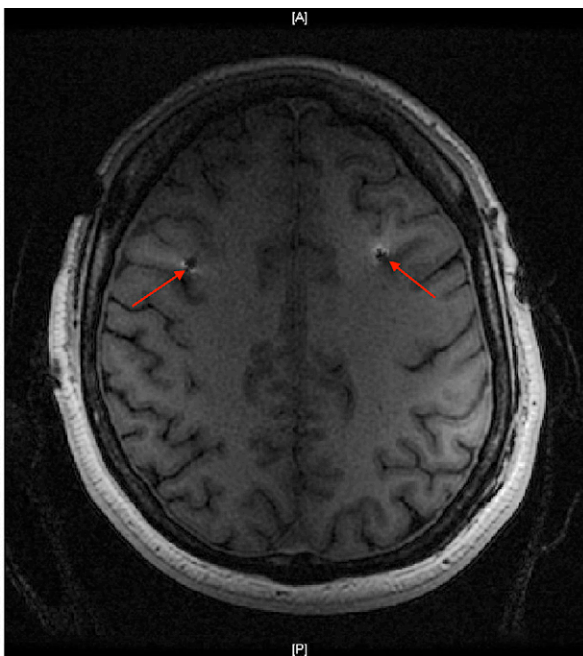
Intraoperative MRI scan shows DBS lead placement (*red arrows*) near the entry site.
